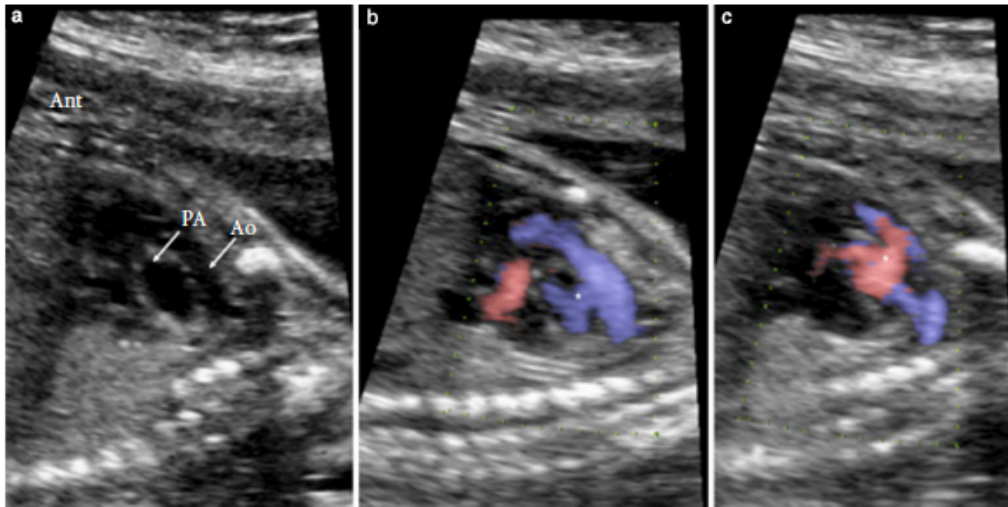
Fetal echocardiography (sagittal view) at 22 + 5 weeks' gestation in Case 2, showing aortopulmonary window (APW) and complete transposition of arteries. (a) With B-mode, APW could not be shown with certainty. (b,c) With e-flow mapping, APW (*) can be seen between aorta (Ao) and pulmonary artery (PA), consistent with postnatal diagnosis. Ant, anterior.
